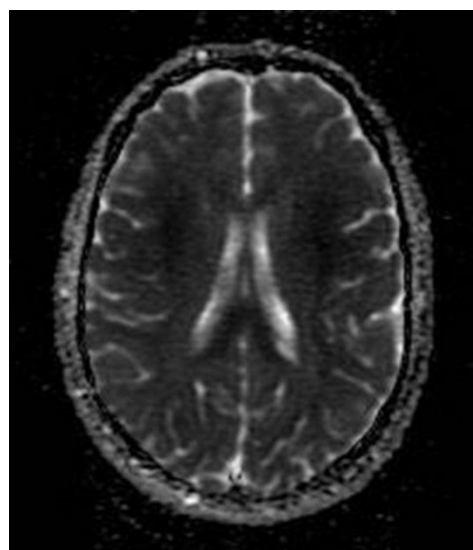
T2-weighted image of the brain showing hyper-intensity over the splenium, the corona radiata and the basal ganglia, with mild diffuse brain edema.
